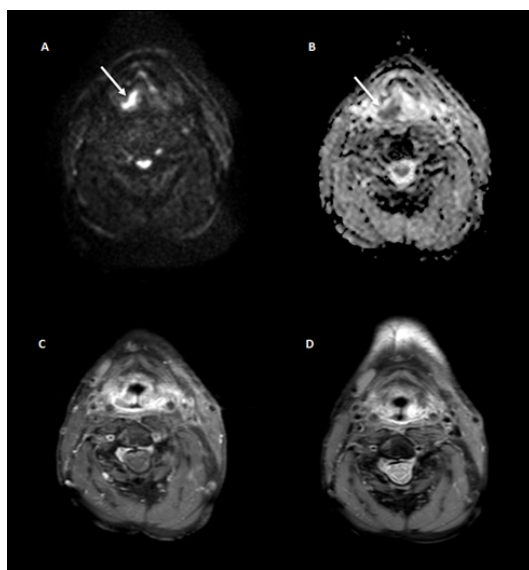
Axial MR images with different contrasts of one of the cases with high interobserver agreement (case 10). Clinical information available to the observers included the following details: 53 year old male with primary T1N0M0 oropharyngeal carcinoma. Sixteen months after treatment with CRT, fiberoptic endoscopy showed an abnormality of the right oropharynx extending into the hypopharynx. The superimposed white arrows indicate regions with low apparent diffusion indicative for diffusion restriction which is suspected for malignancy. The patient had a biopsy proven local recurrence. A: Diffusion weighted $b = 1000 \text{ s/mm}^2$, B: ADC, C: T1w SPIR + Gd contrast, D: PD SPIR.
